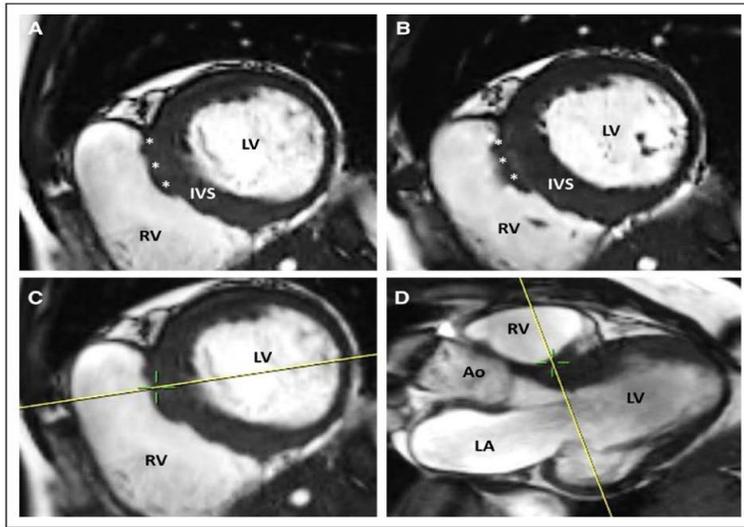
Challenges in measuring wall thickness with CMR. Cardiac magnetic resonance imaging demonstrating how tangential cuts through septum can overestimate interventricular septal (IVS) thickness on long-axis views. In the short-axis view (A), the *yellow line* represents the plane used to obtain the long-axis view (B). This line clearly cuts the muscle tangentially, which will overestimate the septal thickness, while the *red line* represents a more accurate nontangential plane through the compacted IVS thickness.
